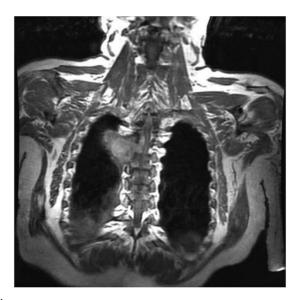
MRI lung cell carcinoma.
